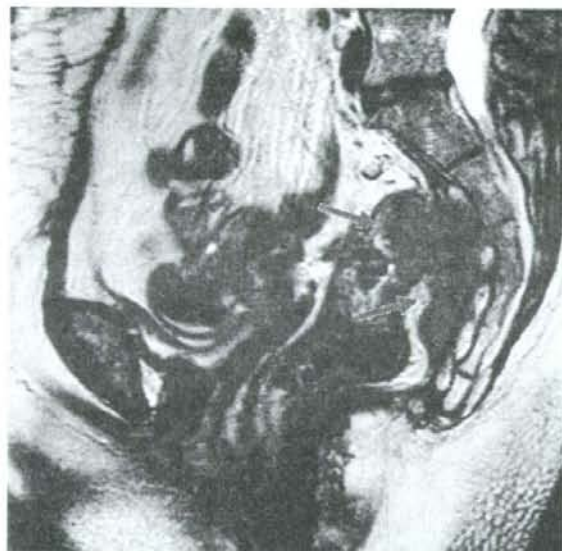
MR image of presacral local recurrence, sagittal MR image of locally recurrent mass in the presacral subsite.
